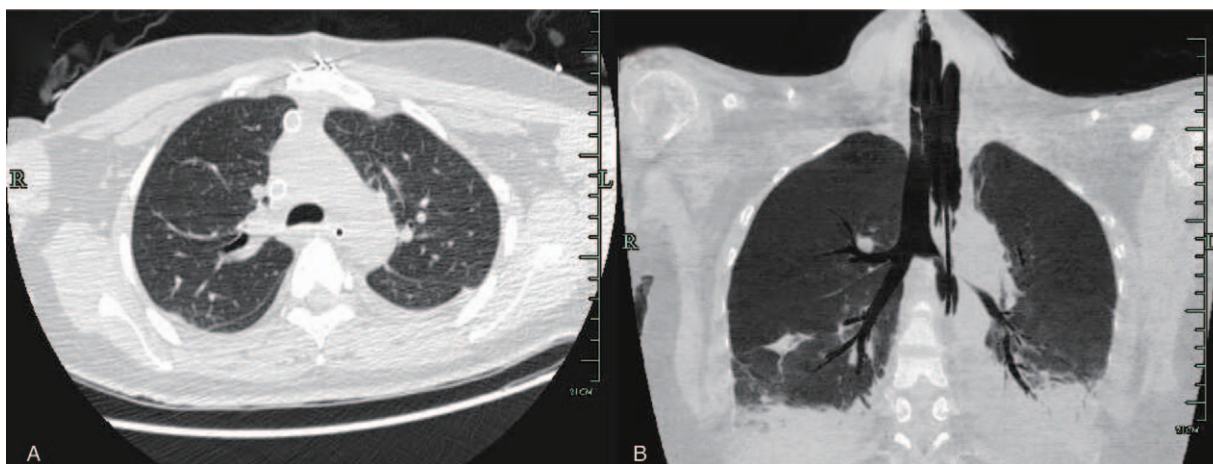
Chest computed tomography (A) and airway reconstruction (B) of the patient 10 days after the operation. The mass in the anterior mediastinum was removed; there was no obvious infection (A), and the airway is unobstructed (B).
